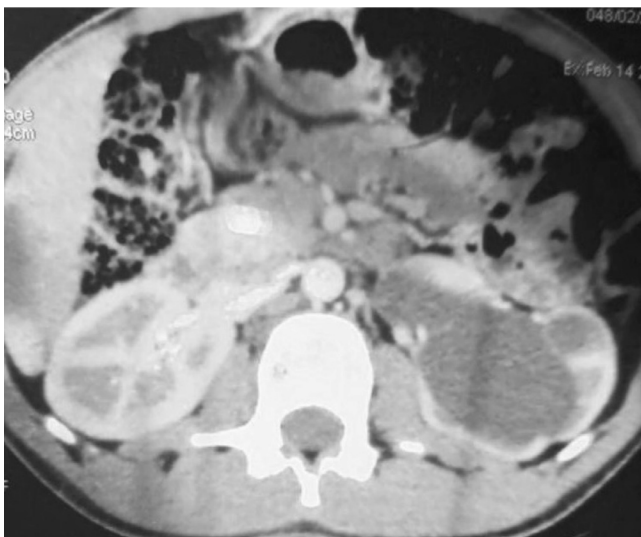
Abdominal CT scan showing a destroyed non-secreting sclerotic kidney.
